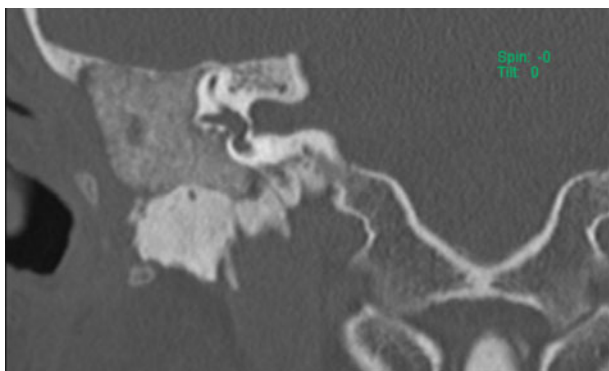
Coronal computed tomography scan of the right middle ear of patient A, showing homogeneous distribution of S53P4 in the surgical cavity of the middle ear and epitympanic space.
